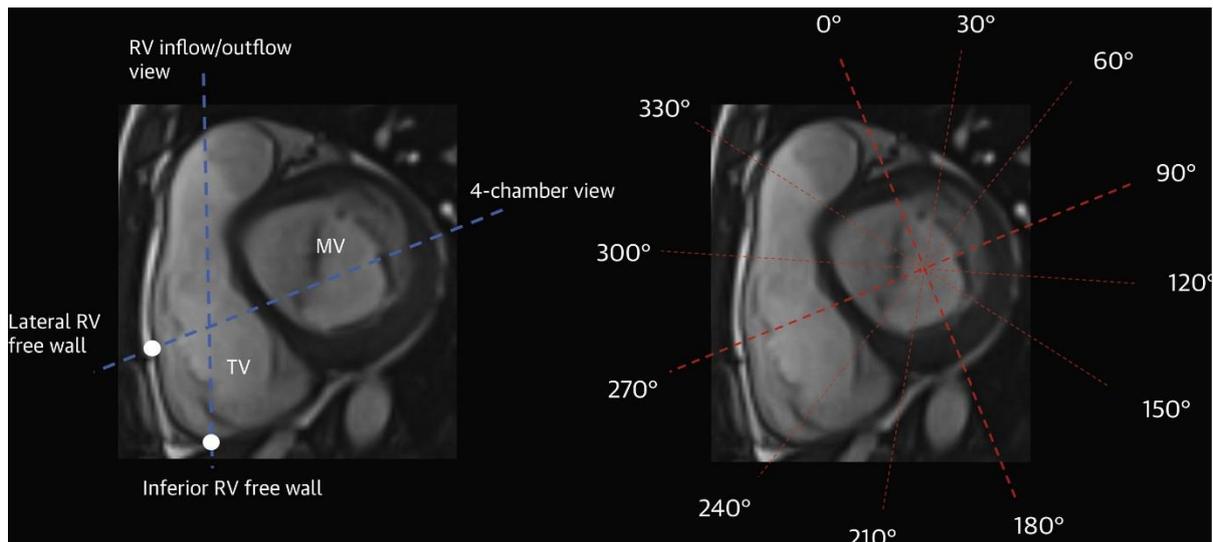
Cardiac magnetic resonance imaging protocols
